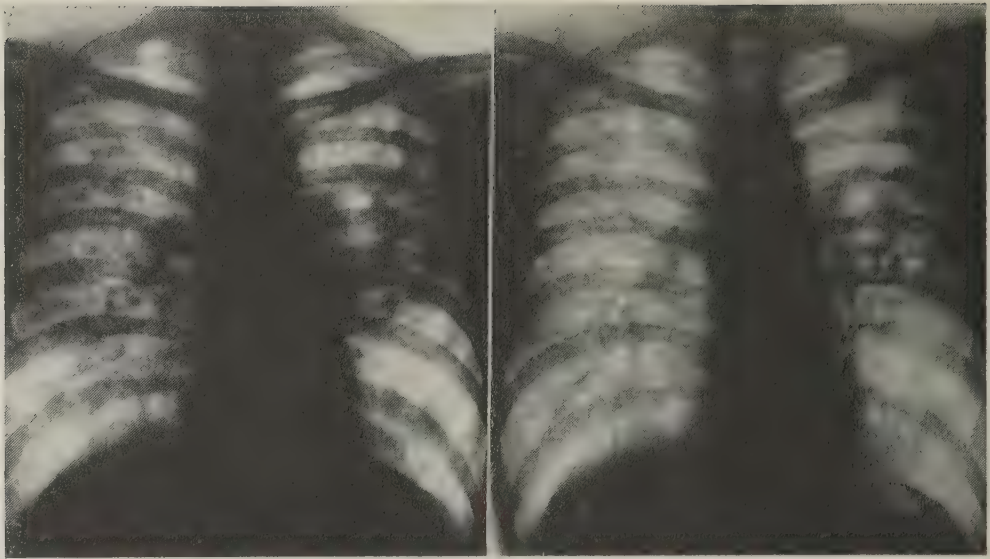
(Left) Roentgenograph of lungs of patient R. M. shows extensive lesions.
